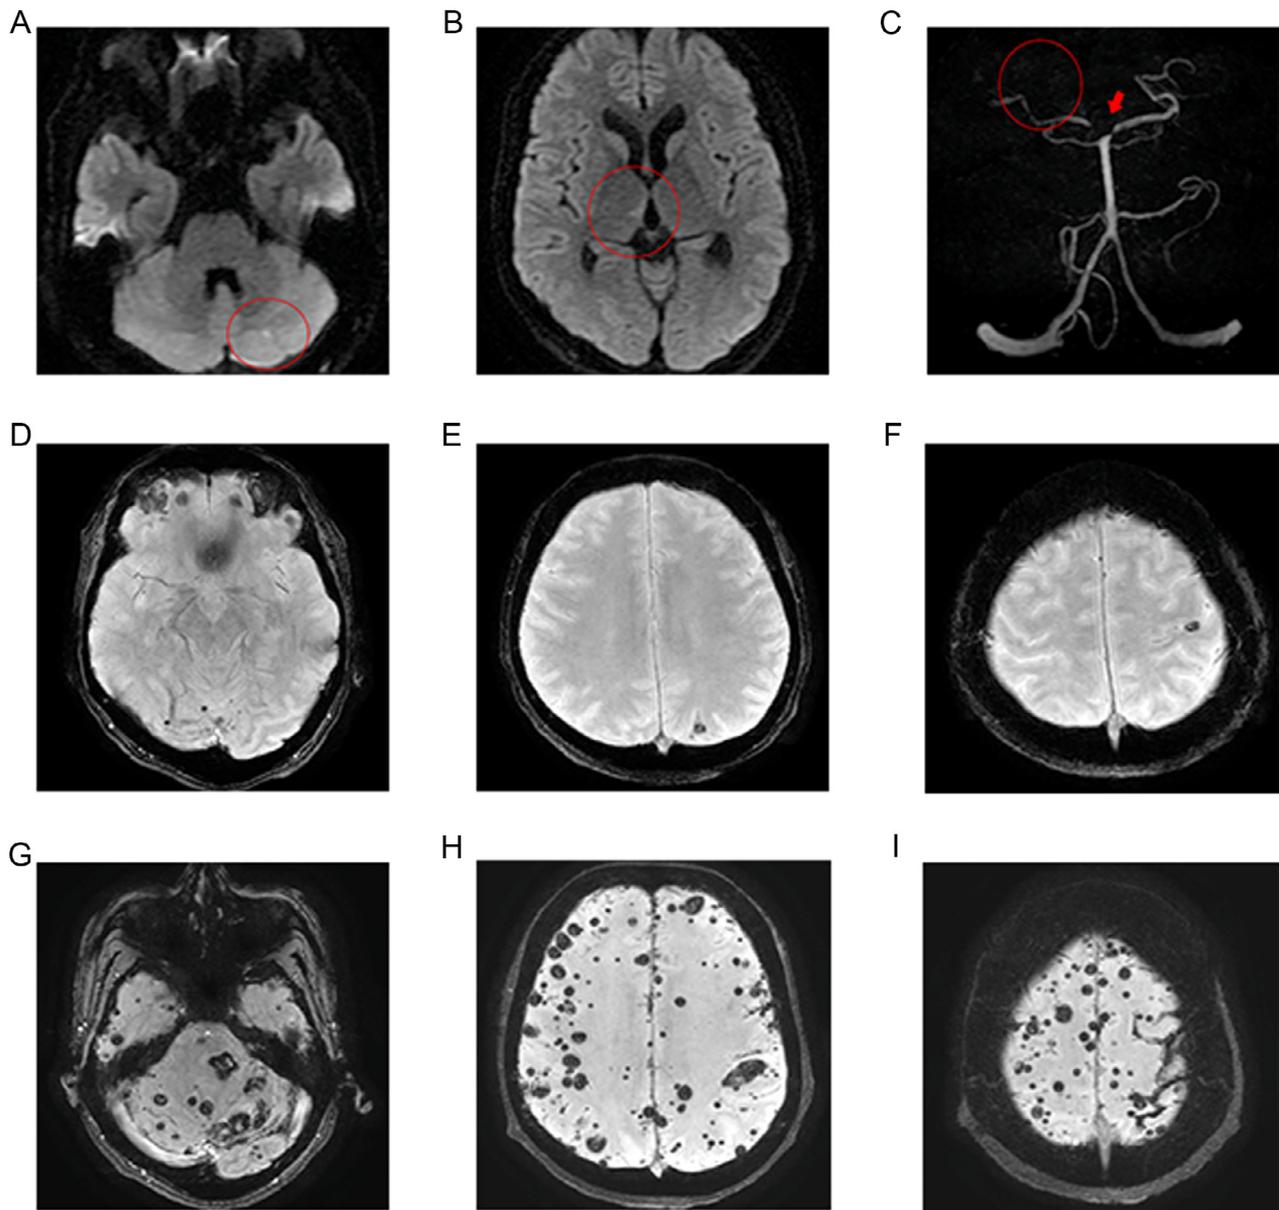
(A and B) Magnetic resonance imaging (MRI) shows right thalamic and left cerebellar infarction (red circle) on diffusion-weighted imaging (DWI). (C) MR angiography (MRA) shows occlusion from the top of the basilar artery (arrow) and distal part of the right posterior cerebral artery (red circle). (D-F) Some hypointense signal spots are detected in the cortex, subcortex, around the sulci, and in the cerebellum on susceptibility-weighted MRI (SWI). (G-I) Postoperative SWI shows catastrophic multiple microbleeds in the cortex, subcortex, around the sulci, and in the cerebellum. (Color version of figure is available online.)
